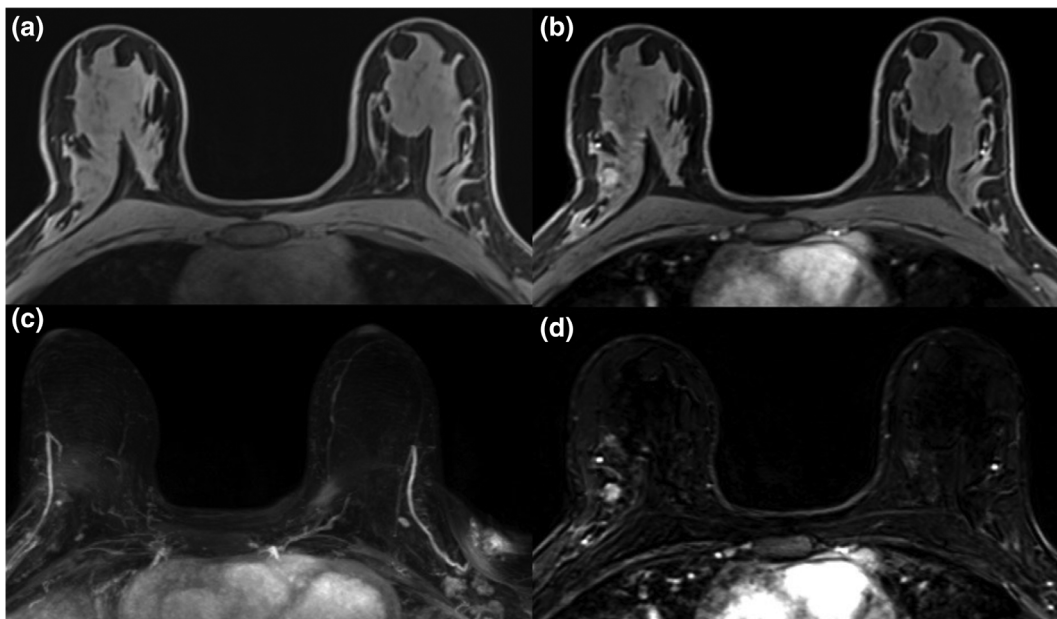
Invasive lobular carcinoma (ILC) in the right breast of a 59-year-old patient. The irregular, spiculated 3.5 cm mass (A) demonstrates heterogeneous contrast enhancement on early contrast-enhanced axial T<sub>1</sub>W (B), maximum intensity projections (MIP) (C), and subtraction images axial T<sub>1</sub>W postcontrast (D) and was accurately diagnosed with an abbreviated MRI protocol.
